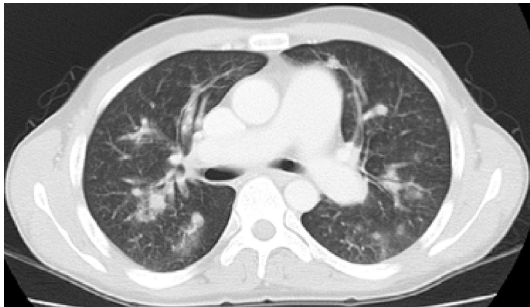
Computed tomography shows multiple pulmonary nodule shadows in whole lung fields.
